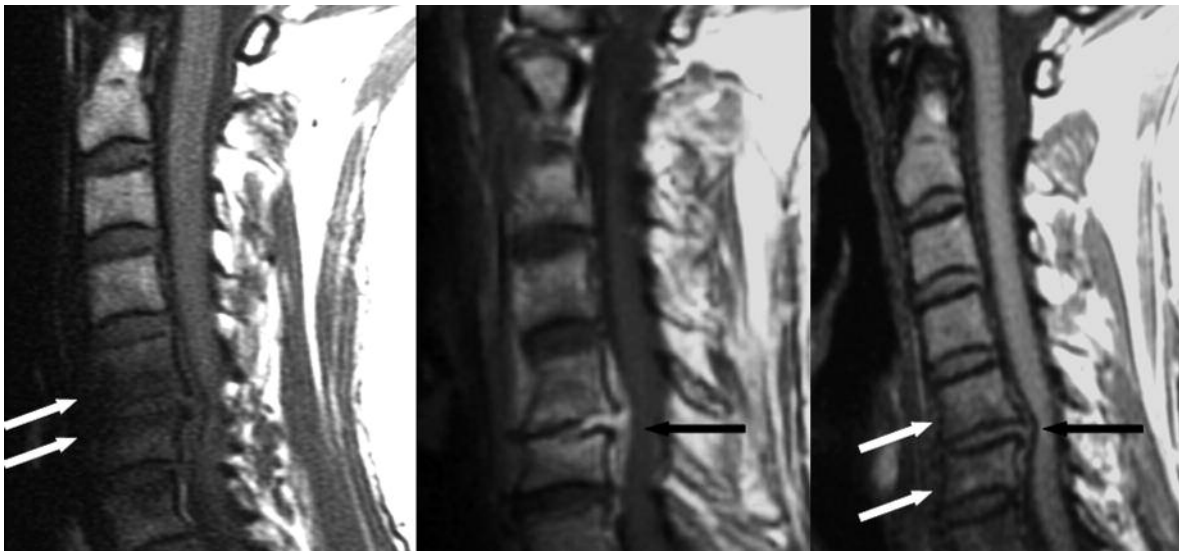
Tuberculous spondylitis in a 52-year-old man. (a) Sagittal T1-weighted image shows decreased signal within the vertebral bodies of C5 and C6 (*white arrows*) and a soft tissue mass posterior to the C5 and C6 bodies (*black arrow*). (b) Corresponding contrast-enhanced T1-weighted image shows uniform enhancement of the epidural collection indicative of a phlegmon (*arrow*) and infective involvement at C5-6 level with enhancement of the affected vertebral bodies and intervertebral disc. (c) Sagittal T1-weighted image obtained after 2 months of chemotherapy. As compared to the previous T1-weighted image the epidural mass is smaller (*black arrow*) and there is an increased signal in the affected vertebral bodies (*white arrows*), the expression of medullary fat replacement indicative for healing.
